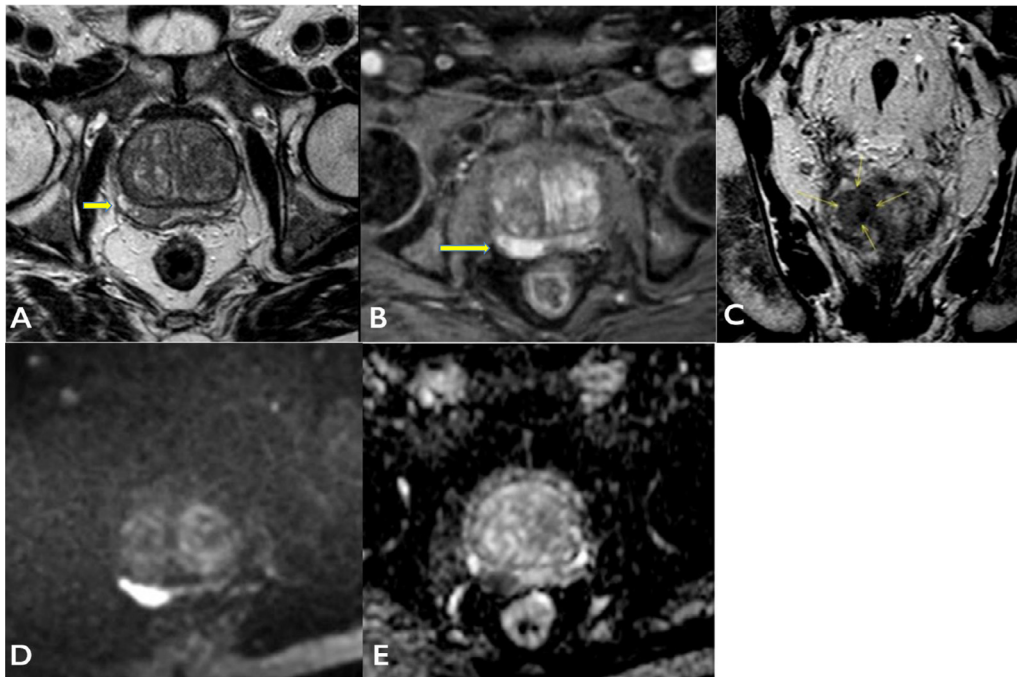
PIRADS 5/5 lesion in the right peripheral zone. (A) Axial T2w image of the prostate. Ill distinct low T2 region in the right peripheral zone (PZ) (arrow). (B) DCE 2 minutes image of the prostate shows avid enhancement in this right PZ (arrow). (C) Coronal T2w image that better demonstrates the focal low T2 lesion (arrows). This is a good example of how an alternative plane can help interpret a low signal area. (D) B1400 DWI image with high signal in the right PZ lesion that indicates marked restricted diffusion, confirmed in the corresponding ADC map E.
